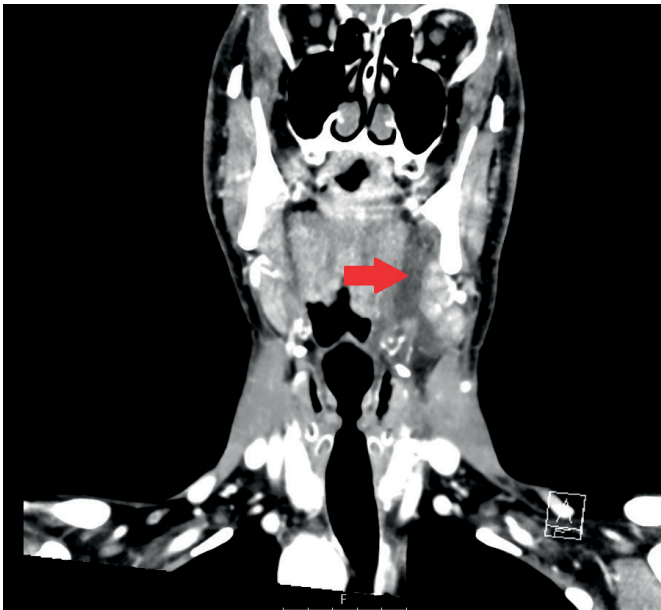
A coronal slice taken from the urgent CT requested after the development of the submandibular swelling. Diffuse fluid buildup can be seen in the left submandibular space, displacing the submandibular gland laterally.
